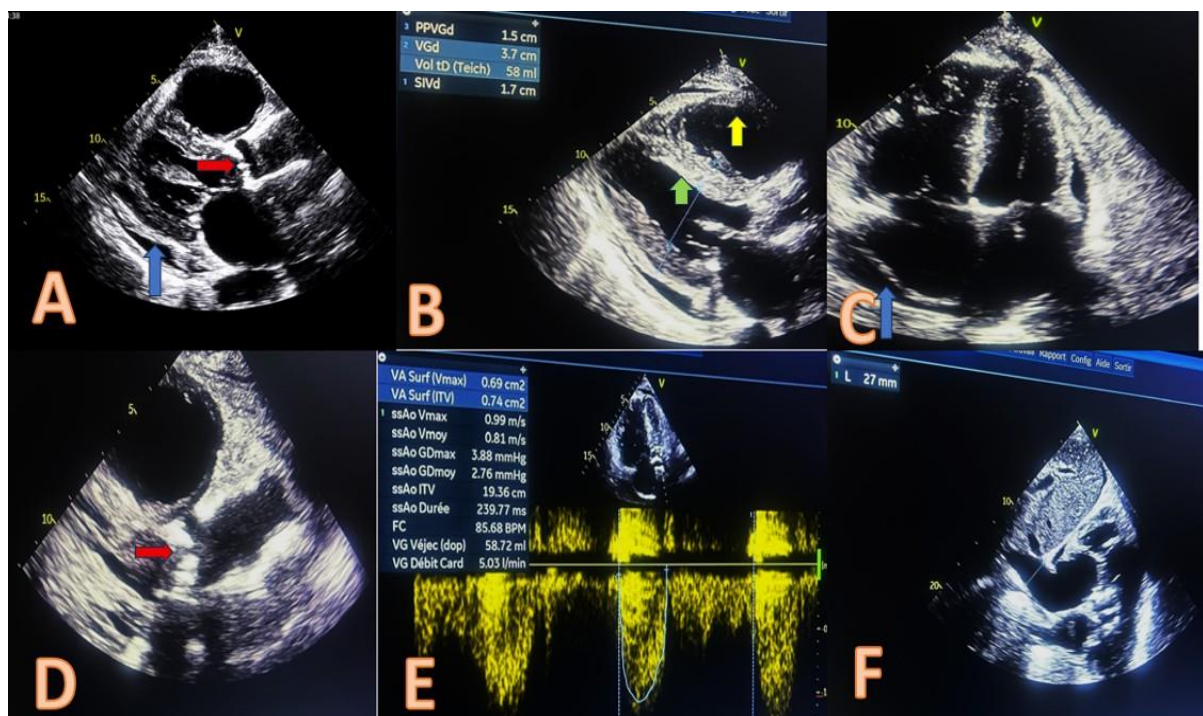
Transthoracic echocardiographic findings of severe calcific aortic stenosis with imaging features highly suggestive of concomitant cardiac amyloidosis
